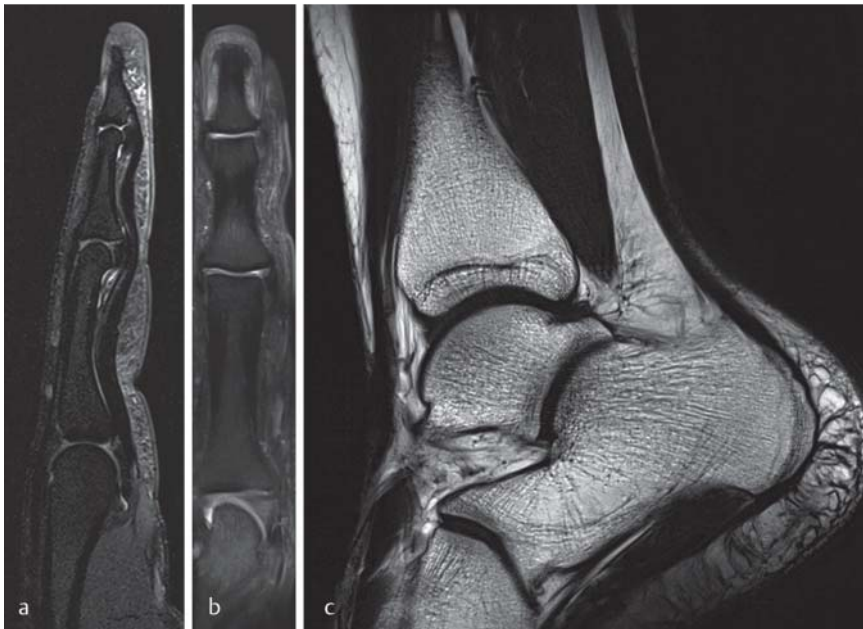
a, b show 7 Tesla sagittal a and coronal b proton density weighted images with fat suppression of a finger, yielding detailed delineation of small finger joints and tendons. c shows 7 Tesla T1 TSE MRI of the ankle joint in sagittal view, providing high quality visualization of the trabecular bone within the tarsal bones with high spatial resolution (Courtesy of Prof. S. Trattnig, MR Centre-High Field MR, Department of Radiology, Medical University, Vienna, Austria).
